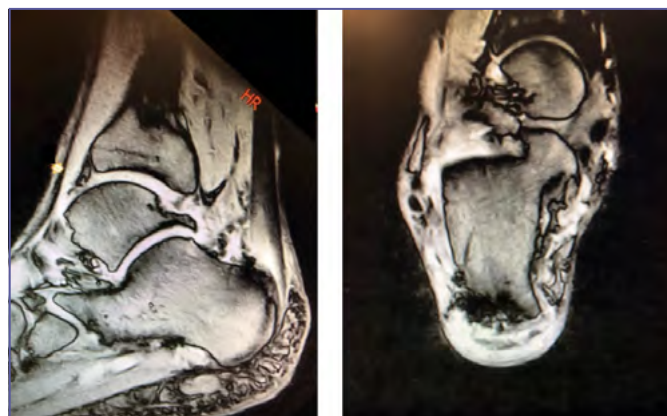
Post-operative MRI of the ankle and posterior heel in lateral and coronal projections. No possible cause of lateral pain persistence was detected. The radiologist described distal Achilles tendinosis with persistent oedema of the tendon and into the Kagher triangle and surrounding tissues.
